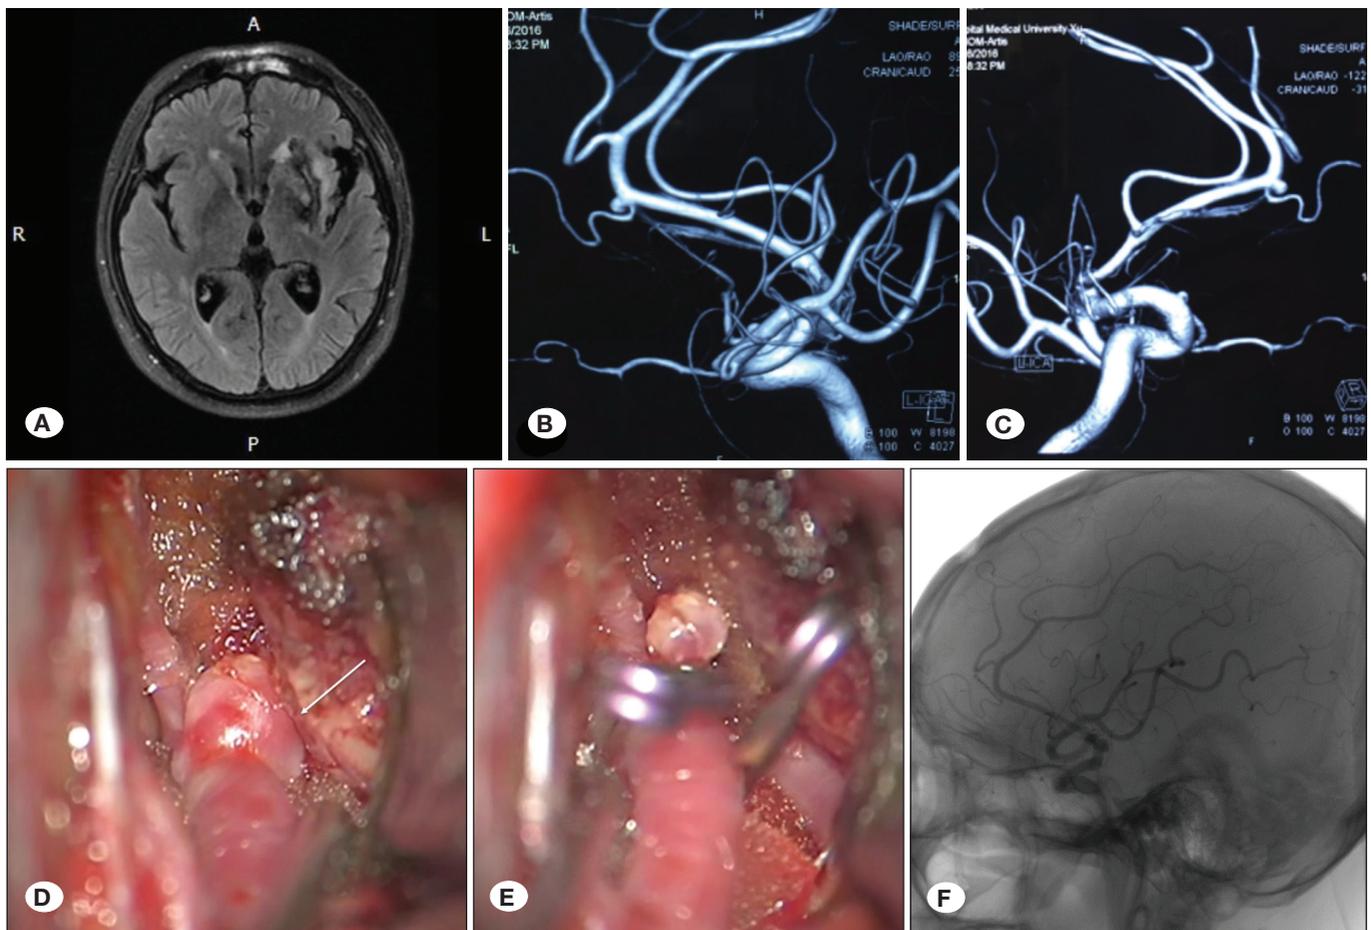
Ruptured PAA as seen on (A) preoperative MRI and (B, C) preoperative DSA. (D) Intraoperative exposure of the PAA; the aneurysm is shown by the arrow. (E) Aneurysm clipping. (F) DSA at 14 months after microsurgery.
